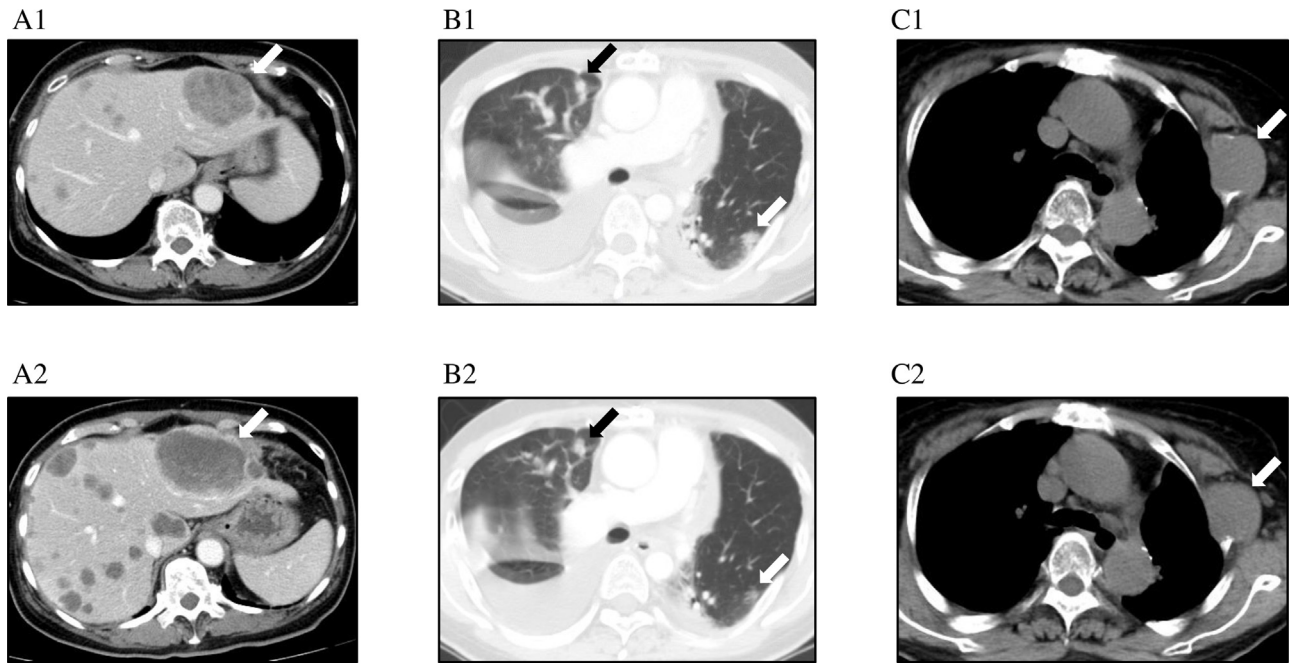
Radiographically changes during sorafenib treatment.
